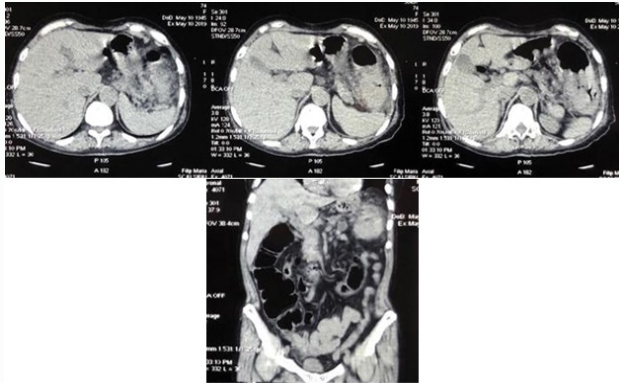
CT AP of the patient.
